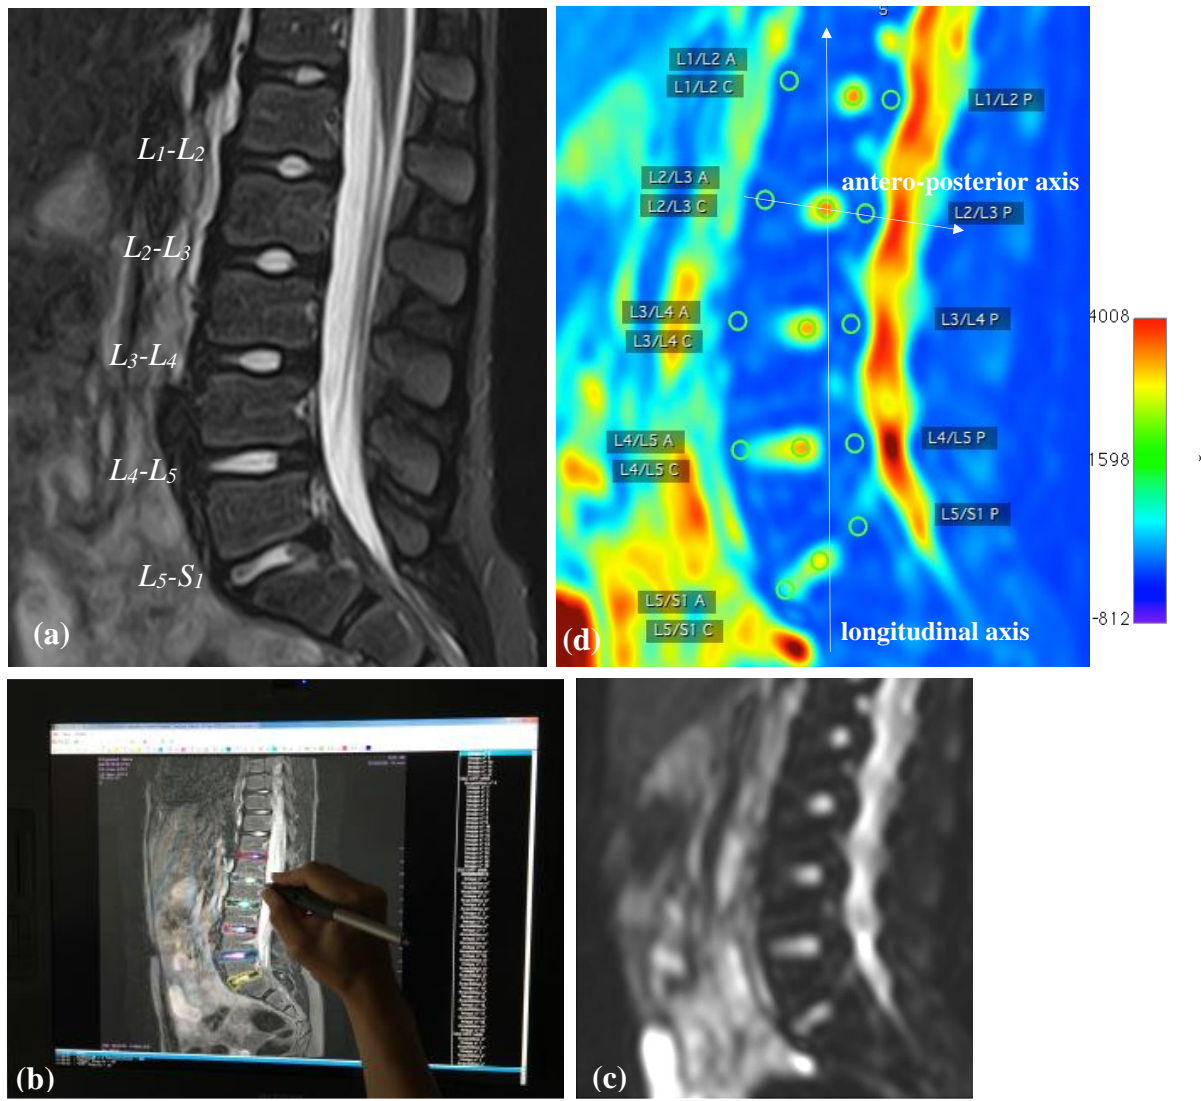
Lumbar MR imaging in the sagittal plane: (a) T2 imaging, (b) Semi-automated segmentation and automated volume reconstruction of IVD from MRI slices using tactile device Wacom® Cintiq 21 UX, (c) STIR imaging, (d) Map of ADC ($10^{-6} \text{ mm}^2/\text{s}$, *grayrainbow clut*) showing ROIs in nucleus pulposus (NP), anterior annulus fibrosus (AAF) and posterior annulus fibrosus (PAF).
